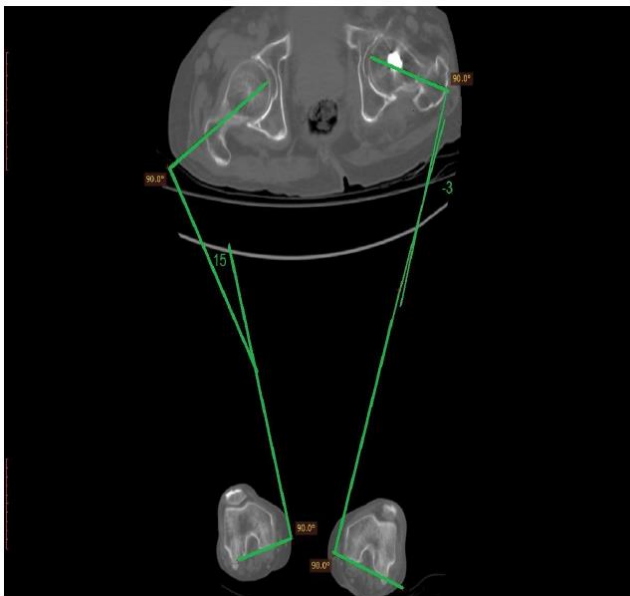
CT measurement of healthy and operated side.
